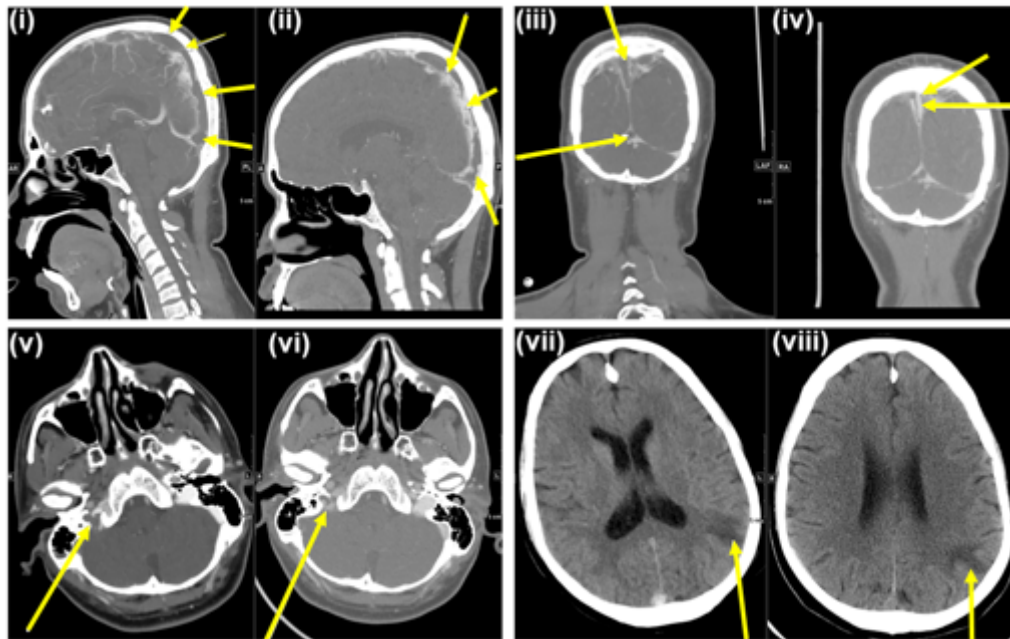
CT brain showing CVST at presentation (i, iii, v and vii arrows) vs no CVST at discharge (ii, iv, vi and viii arrows): i) and iii) brain CT scan showing superior sagittal sinus and confluence of sinuses thrombosis with collaterals suggestive of CVST vs ii) and iv) improved CT scan at discharge; v) and vi) brain CT scan showing right jugular bulb thrombosis at presentation vs with partial recanalization at discharge; vii) and viii) left parietal venous infarct at presentation vs at discharge.
